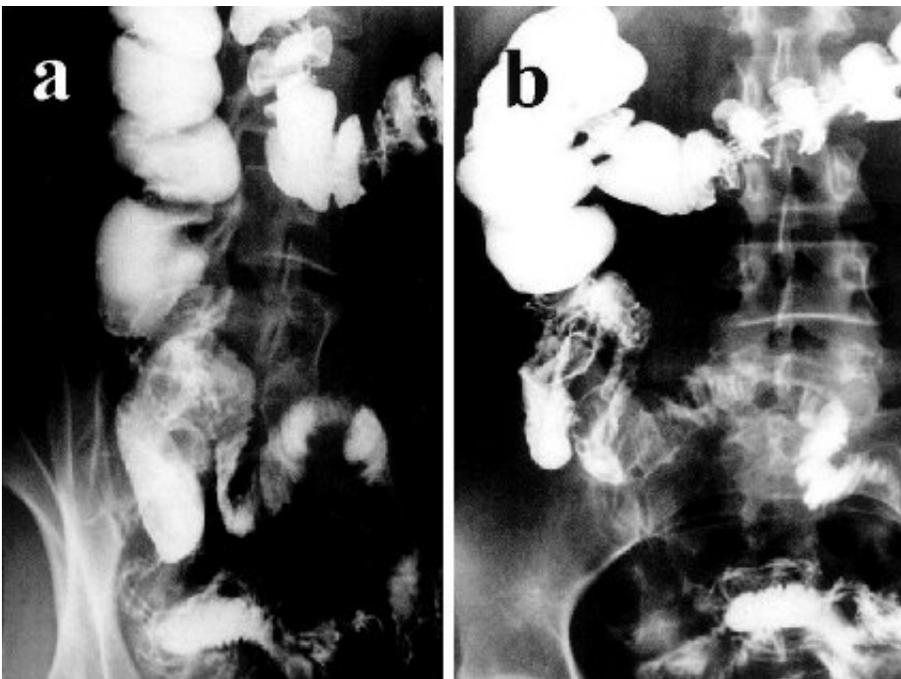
a, b) Abdominal x-rays after 8 months from the operation. Large colon-ileal reflux without ileal spasms and without filling defects in the caecum-colic area.
